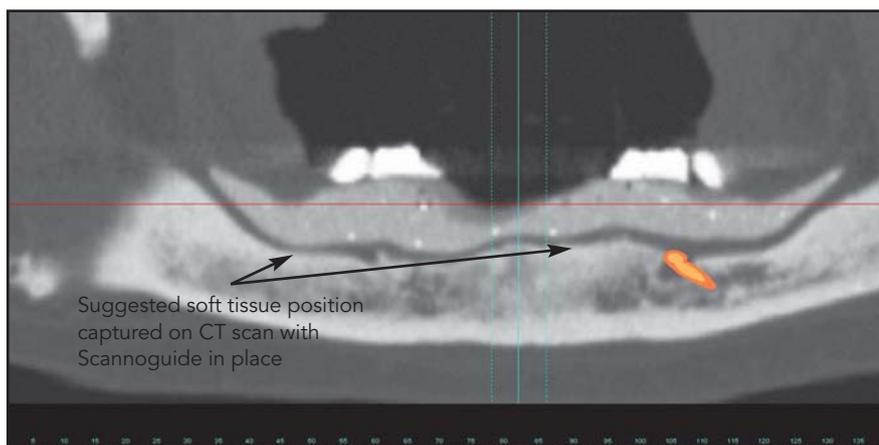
Panoramic view of SimPlant analysis of patient's mandibular CT scan. The Scannoguide is in place, demonstrating a differential barium concentration gradient in the denture base versus the teeth. Note the absence of air pockets between the denture base and the mandibular jawbone, which suggests accurate adaptation of the Scannoguide to the mucosa.
